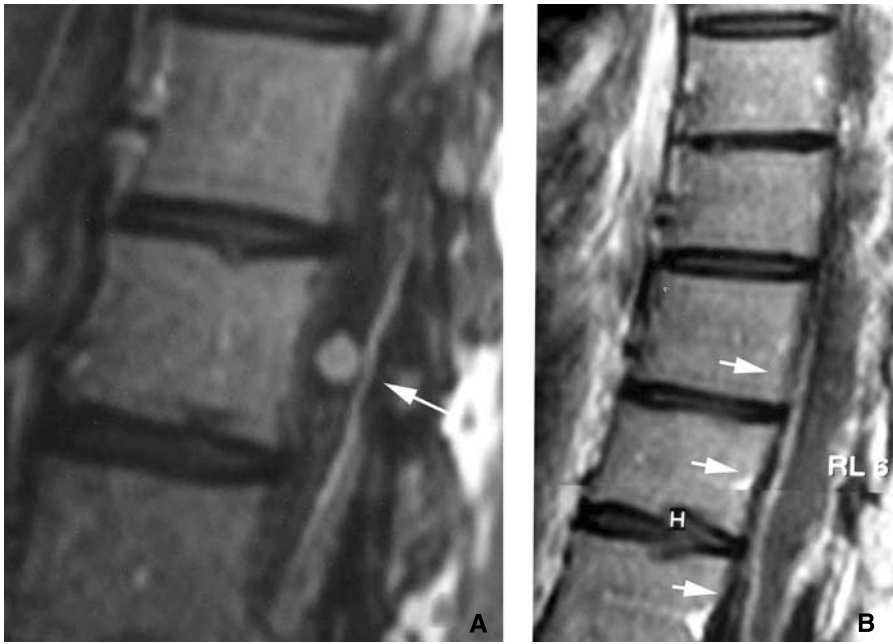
Gadolinium enhanced T1-weighted MRI showing a “drop” metastasis (A), and diffuse leptomeningeal enhancing in the conus medullaris and cauda equina (B)
